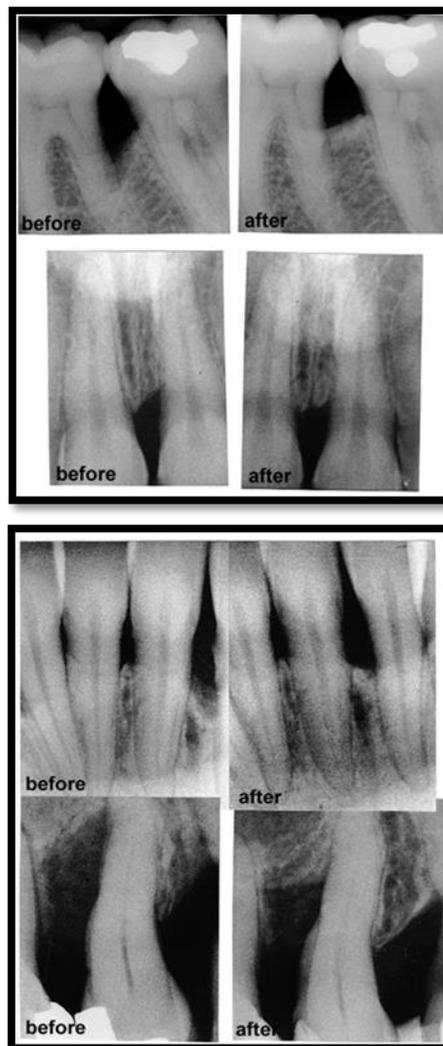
IOPA Xrays showing the success of TIP
